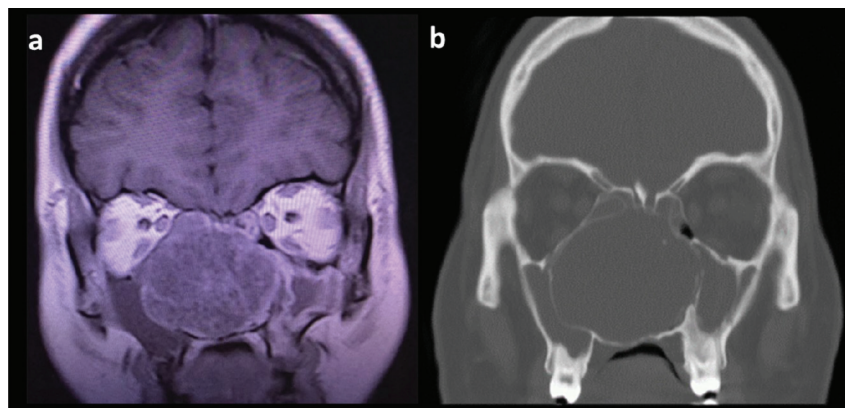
(a) MRI, T1-weighted coronal plane depicts hypointense lesion with peripheral enhancement. (b) Coronal section CT scan with bone window demonstrating the expansive lesion with thinning of peripheral bone.
